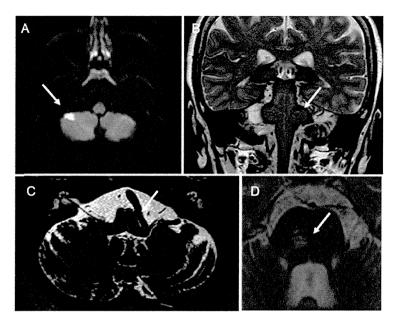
MRI findings of patients with chronic dizziness. A: AICA syndrome in a 64 year-old female with a history of paroxysmal atrial fibrillation, B: Superficial siderosis in a 60 year-old female, C: Dolichoectasia of the vertebrobasilar artery in a 49 year-old male, D: Pontine infarction in a 65 year-old man with a history of hypertension. The arrows show lesioned areas.
